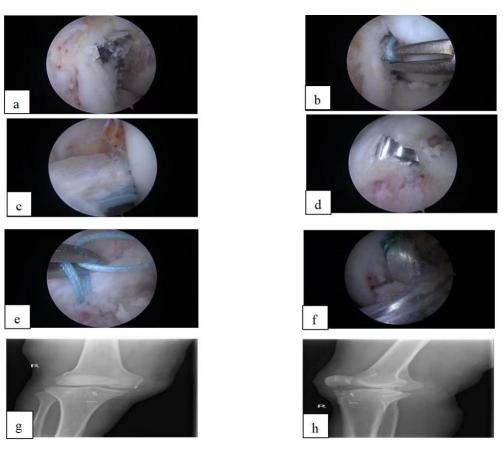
ACL reconstruction. a: A flexible reamer with the same diameter as the graft; b,c: Femoral socket making. d: Tibial socket creation of ACL was achieved by flexible reamer; e: The wires were passed through the socket. f: The ACL and PCL after reconstruction. g.h: X-ray film after the operation.
